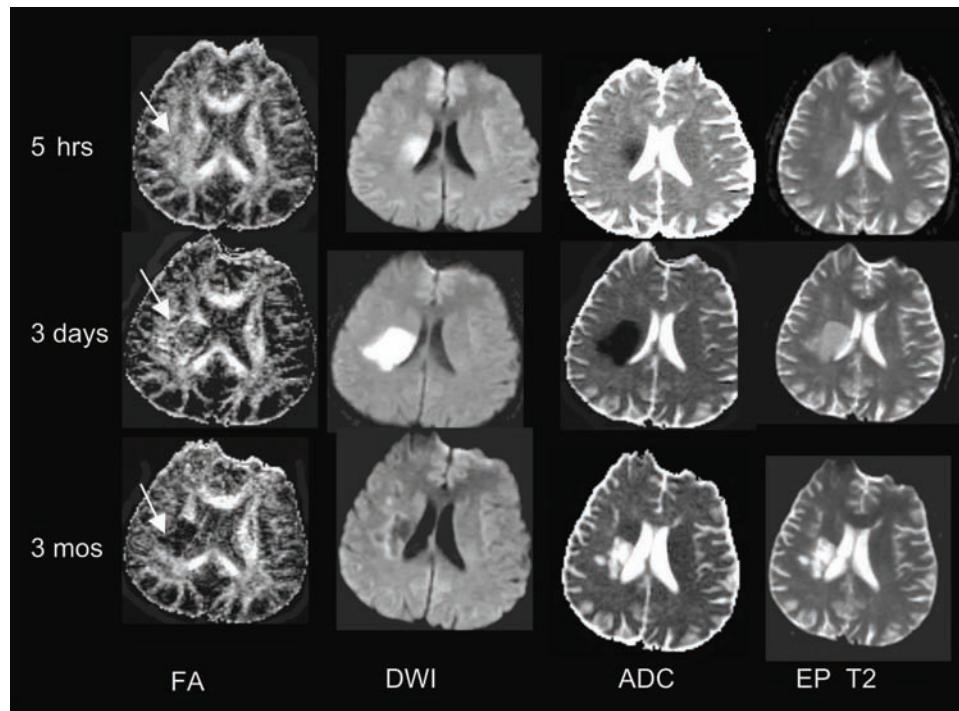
Temporal evolution of FA in acute ischemia. A 50-year-old male with left hemiparesis was imaged at five hours, three days, and three months following symptom onset. At five hours, the right corona radiata and caudate stroke are hyperintense on FA and DWI images (arrow), hypointense on ADC images, and not seen on echo planar T2-weighted images. These findings are consistent with the first stage of FA changes in stroke described by Yang et al. After three days, the lesion is hypointense on FA images, hyperintense on DWI images, hypointense on ADC images, and hyperintense on echo planar T2-weighted images. These findings are consistent with the second stage of FA changes in stroke. At three months, the lesion is hypointense on FA images, hypointense on DWI images, hyperintense on ADC images, and hyperintense on echo planar T2-weighted images. These findings are consistent with third stage of FA changes in stroke. Abbreviations: FA, fractional anisotropy; ADC, apparent diffusion coefficient; DWI, diffusion-weighted images.
